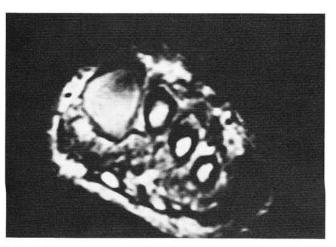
T1-weighted sequence with decreased signal intensity.
